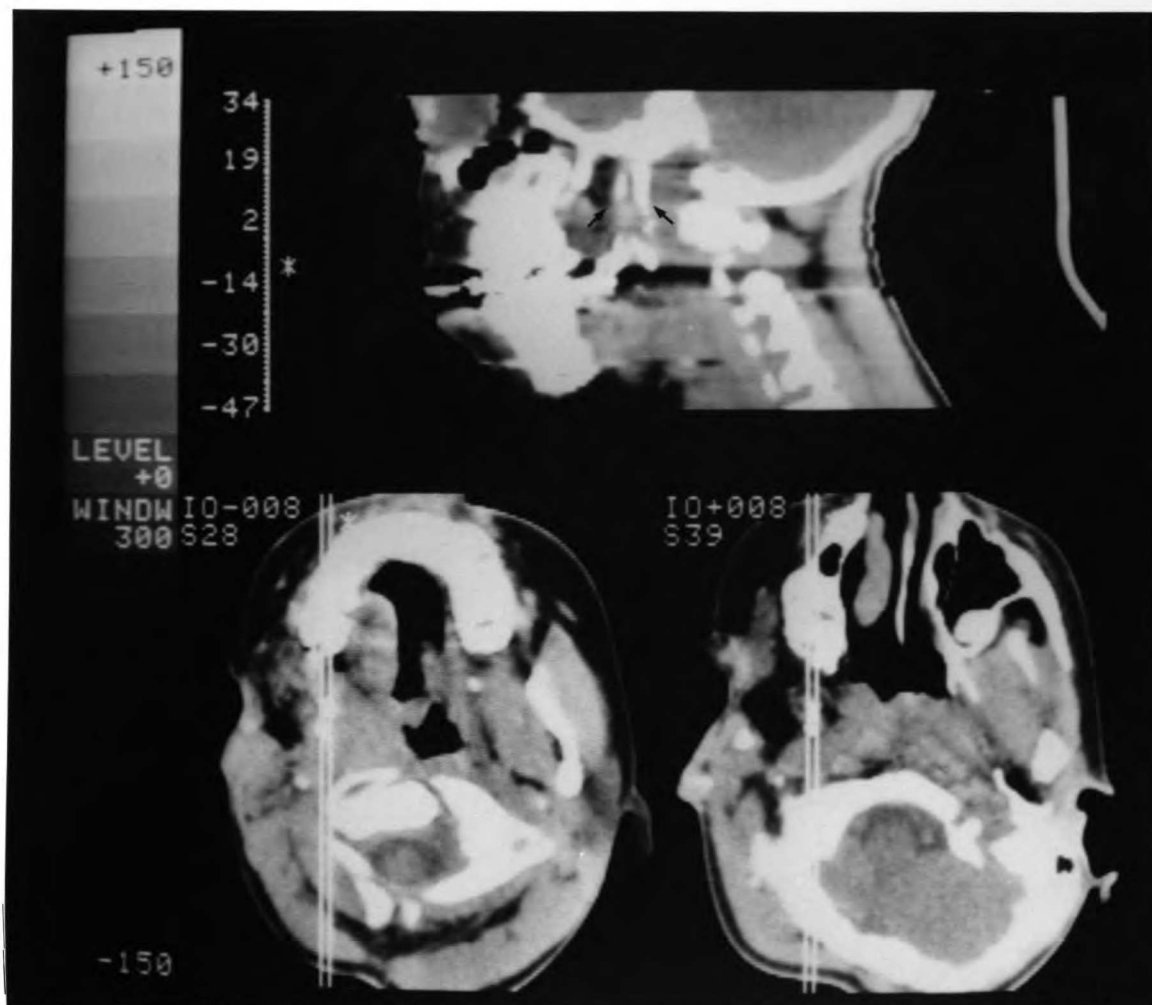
Construction of a para-sagittal CT image from two pre-tx axial CT images. All three images are from HFM patient #1. The lower right image (S39) is the same pre-tx image seen in Figure 10; the lower left image (S28) is from 15 mm. inferior to S39 at the level of the maxilla. The two white parallel lines indicate from where the para-sagittal plane was reconstructed. Note that this plane bisects the two unidentified calcified structures mentioned in the text. The resultant para-sagittal image is seen as the top image and the two small black arrows point out the unidentified calcified structures.
